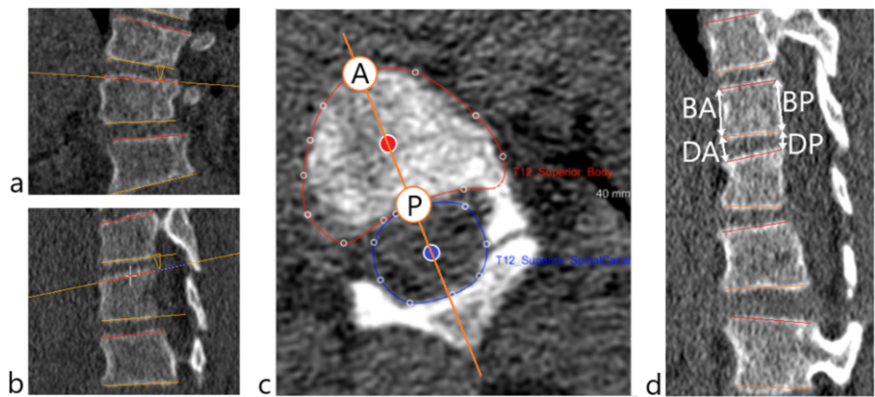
The method to determine the 3D orientation of the lower and upper endplates of included vertebrae in the compensatory thoracic curve is shown. CT-scans were assessed with use of semi-automatic software. First, the view was adjusted for coronal (a) and sagittal (b) tilt. Next, in the true transverse plane of the endplate, the vertebral body and spinal canal were manually segmented (c). The software automatically calculated the midpoint of the vertebral body and the spinal canal, and drew a line through both points to get the true anterior-posterior axis. The intersection of this axis with the vertebral body segmented cortex are the anterior (A) and posterior (P) landmarks of the endplate. This was done for all lower and upper endplates in the thoracic compensatory curve and 3D coordinates of all anterior and posterior landmarks were gathered. Finally, distances between them were calculated: the body-anterior (BA) length, body-posterior (BP) length, disc-anterior (DA) length and disc-posterior (DP) length (d).
